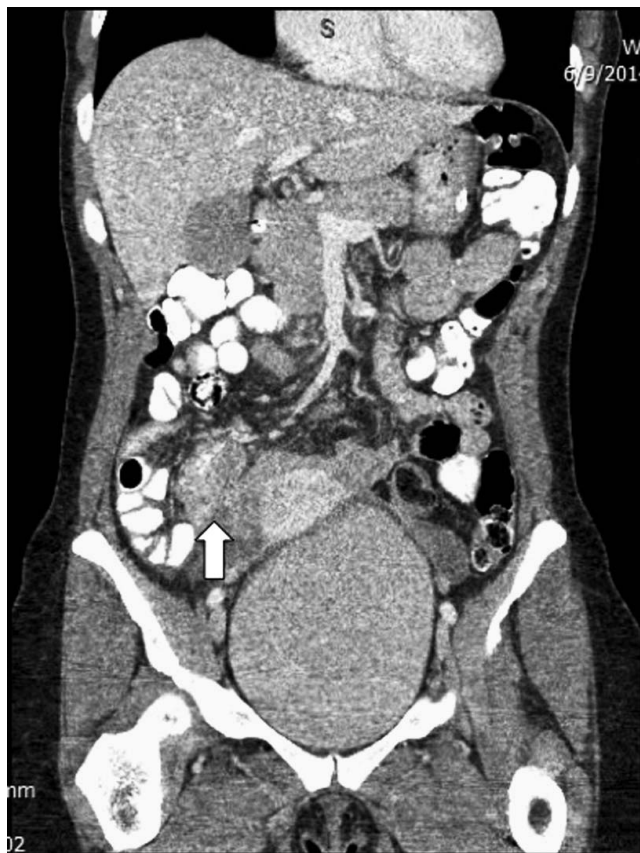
Coronal computed tomography with oral and intravenous contrast displays a right adnexal mass (arrow).
